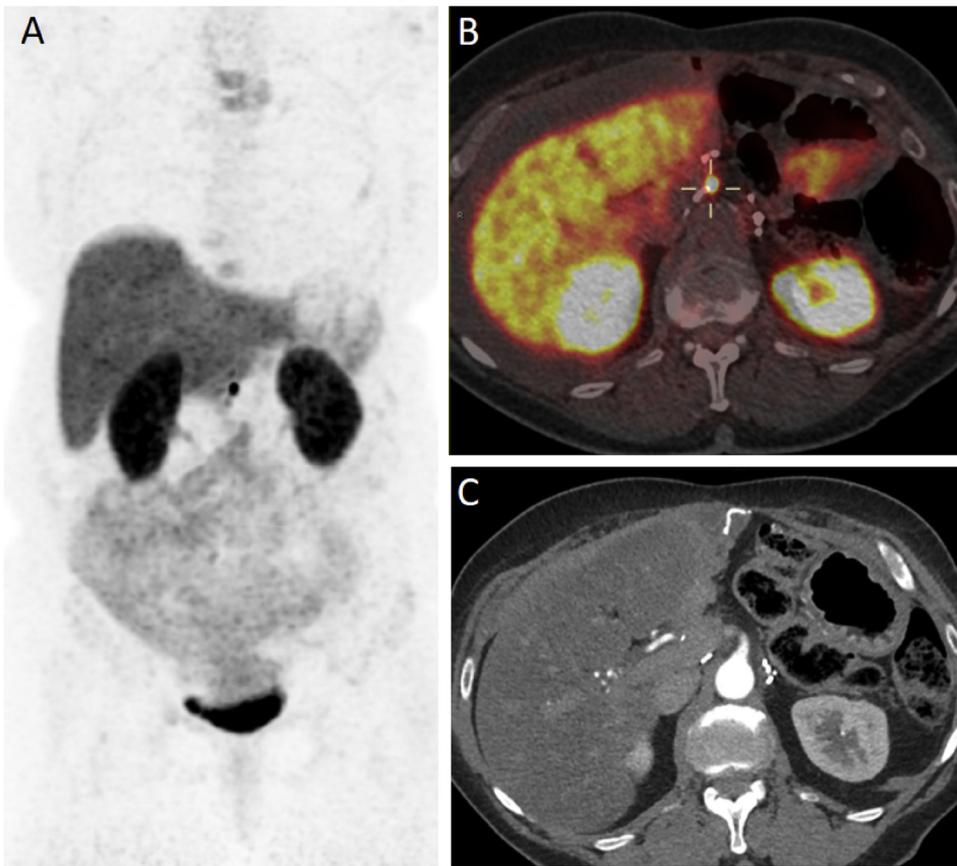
Extra-pancreatic lesion, suspected as a recurrence of pancreatic neuroendocrine tumor in a previous surgery bed, detected by ^{68}Ga -DOTATATE PET/CT, but not by CT scan. (A) Coronal maximal intensity projection (MIP), and transverse image of ^{68}Ga -DOTATATE PET/CT (A & B) demonstrating a lesion very clearly, and a transverse view of early arterial phase of CT scan, not demonstrating the lesion. CT, computerized tomography; PET, positron emission tomography.
